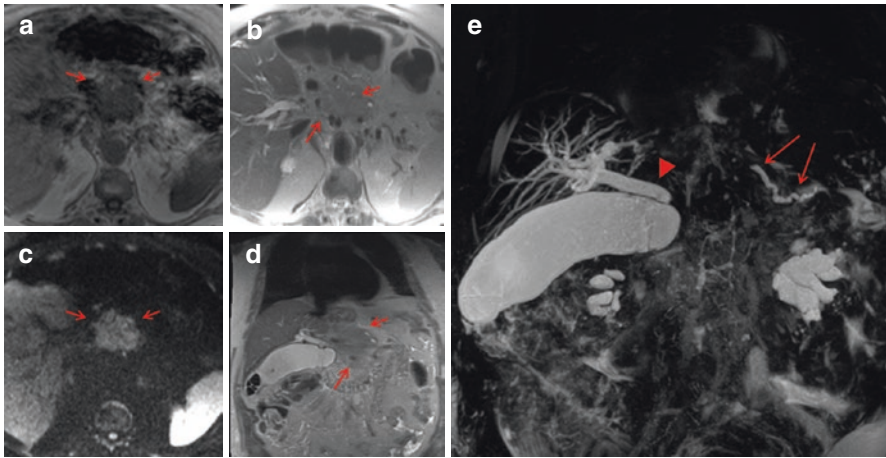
Example of MRI protocol for pancreatic cancer evaluation: Male, 80 year with large non resectable pancreatic adenocarcinoma (short arrows) with bone metastases (not shown): (a) Axial T1-weighted, (b) Axial T2-weighted single-shot fast spin-echo, (c) Axial DWI, (d) Coronal T2-weighted single-shot fast spin-echo, and (e) Coronal 3D MR cholangiopancreatography (MRCP). Note the “double duct sign”: dilatation of the main pancreatic duct (long arrows) and common bile duct (arrowhead)
